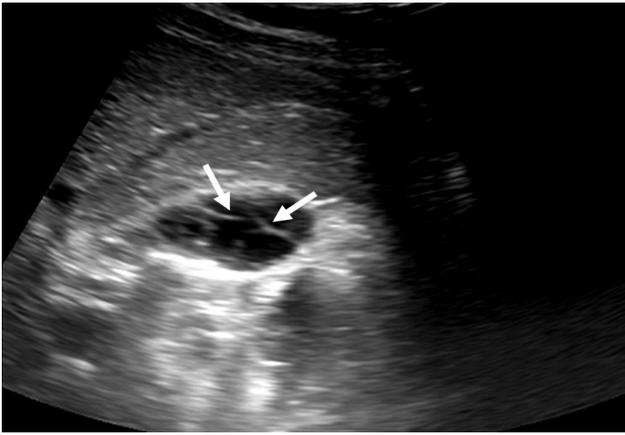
Sagittal sonograms show multiple septa within the fundus of gallbladder, bridging septa seems as a honeycomb pattern. This pattern is typical for multiseptate gallbladder. Note that some septa cross the neck of gallbladder (white arrows).
